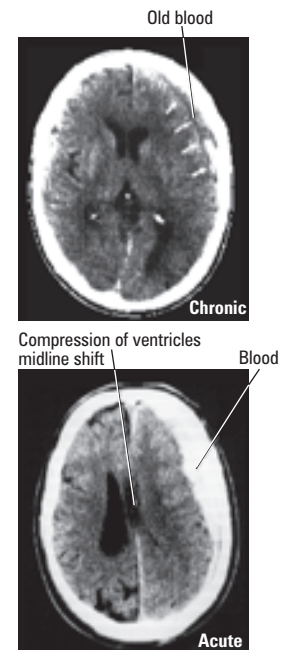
Subdural Hematoma on CT
